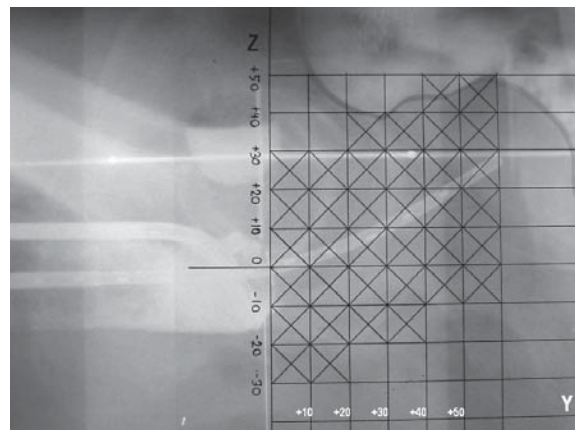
Show radiograph in lateral view with calculated points in Y and Z axis (before bladder distension)
